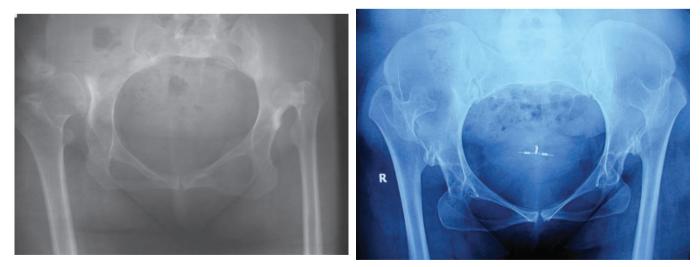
AP pelvis radiographs bilateral Crowe 4 hips
